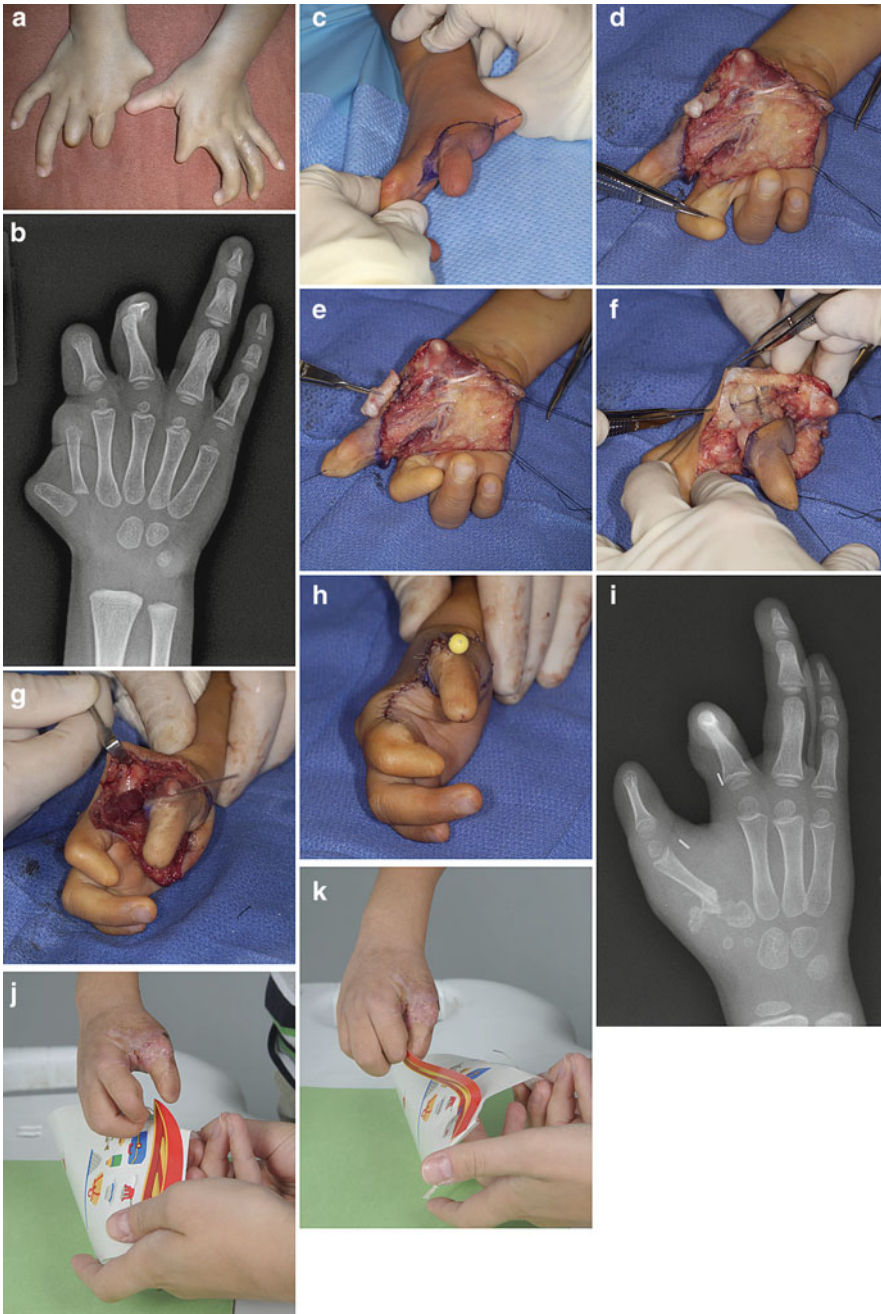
Three-year-old male with brachydactyly of both hands (Courtesy of Shriners Hospitals for Children, Philadelphia). (a) Right hand is missing the terminal portions of the thumb, index, and long finger. On-top-plasty with placement of the index finger on top of the thumb was recommended. (b) X-rays coincide with clinical picture. Thumb with adequate carpometacarpal joint and extra metacarpal between thumb and index. (c) Skin design for
